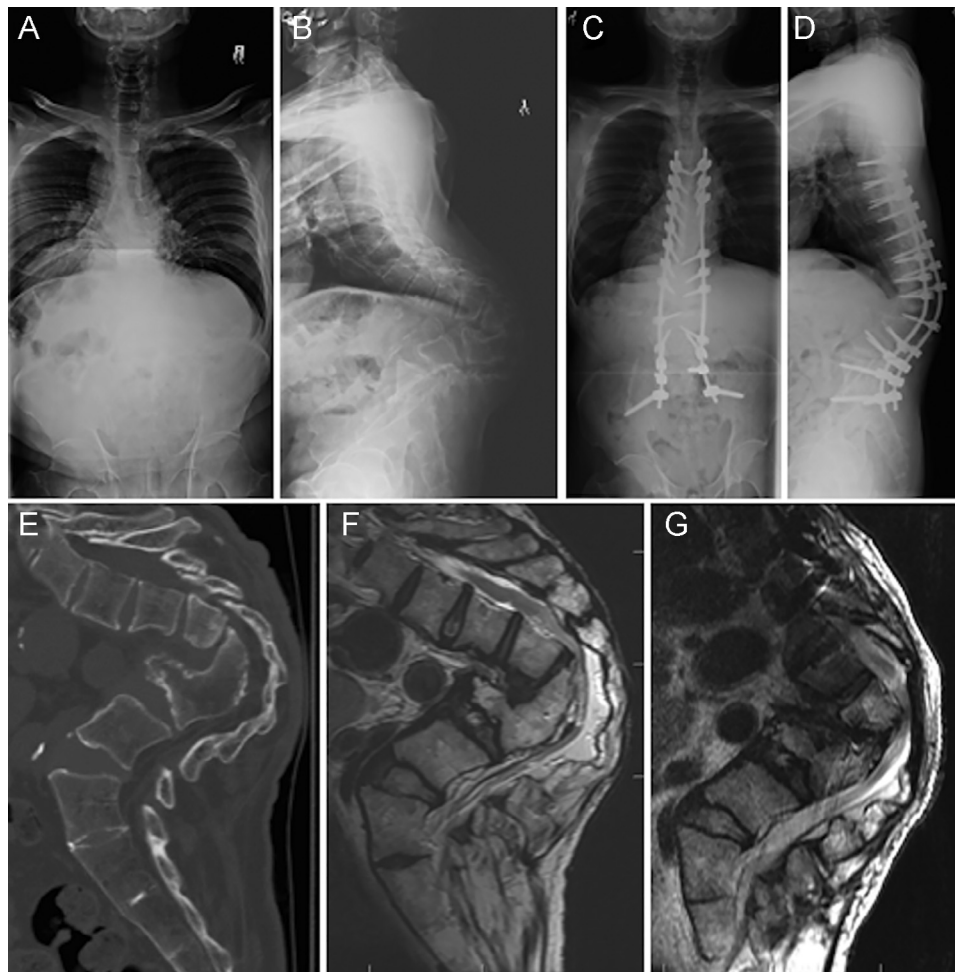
A 59-year-old man presented with postinfectious kyphoscoliosis (likely caused by treated tuberculosis) associated with fusion of L1–L4 vertebrae and a severe kyphotic deformity with neural compression. Preoperative and 1-year postoperative coronal (A) and sagittal (B) x-rays and computed tomography image (E). The local coronal Cobb angle was  $15^\circ$  (DAR 3.0), and the sagittal Cobb angle was measured as  $151^\circ$  (DAR 30.2). This patient developed intermittent claudication with an LEMS of 47 caused by cauda equina compression at the apex of the deformity as shown by the T2-weighted sagittal magnetic resonance image (F). Decompression in conjunction with deformity correction by posterior T12–L1 vertebrectomy and instrumented fusion from T5 to L2 was performed with preservation of all nerve roots. The estimated intraoperative blood loss was 2,200 cc. Coronal (C) and sagittal (D) x-rays 1 year after surgery are shown. Local sagittal Cobb angle was corrected by  $40^\circ$ , and decompression was confirmed by postoperative magnetic resonance imaging (G). Although no neurophysiological changes were observed intraoperatively, the patient experienced lower limb paresis immediately after the surgery (LEMS 27). After an in-hospital physiotherapy program, neurologic function gradually recovered, and the patient presented at a follow-up appointment at 6 weeks with significant improvement (LEMS 42). There was complete neurologic recovery at the 12 months' postoperative follow-up assessment (LEMS 50). DAR, deformity angular ratio; LEMS, lower extremity motor score.
